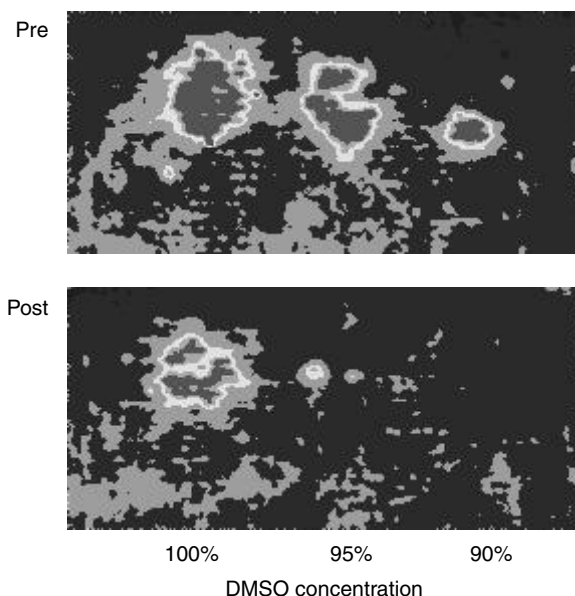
The laser Doppler imager generates a pseudo-colored image of blood flow. In this gray scale image the various shades of grey represent regions with increased blood flow. The dark background represents the baseline blood flow. At baseline DMSO evoked a dose dependent increase in cutaneous blood flow. After 6 weeks of treatment with a water-in-oil emulsion the DMSO response was markedly reduced.
